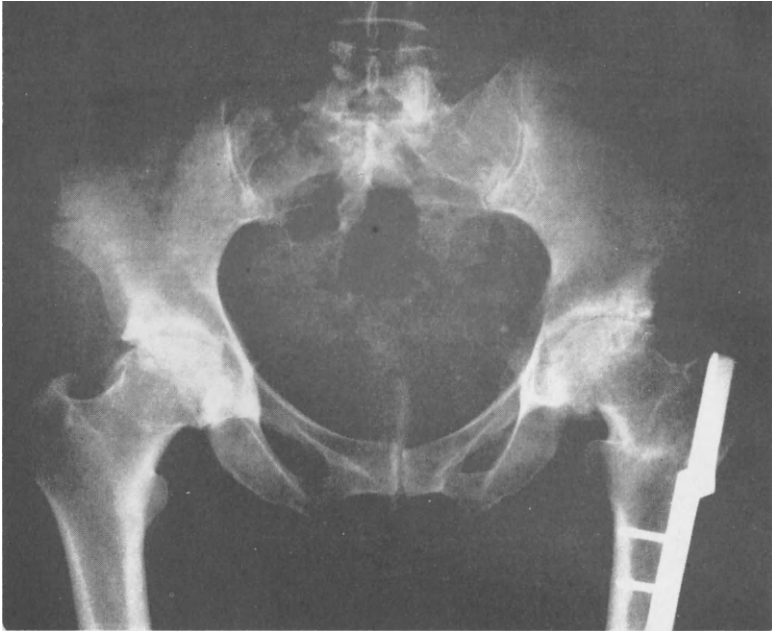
X-ray of female pelvis. An osteotomy has been performed on the left hip joint and a metal plate screwed into the femur.
